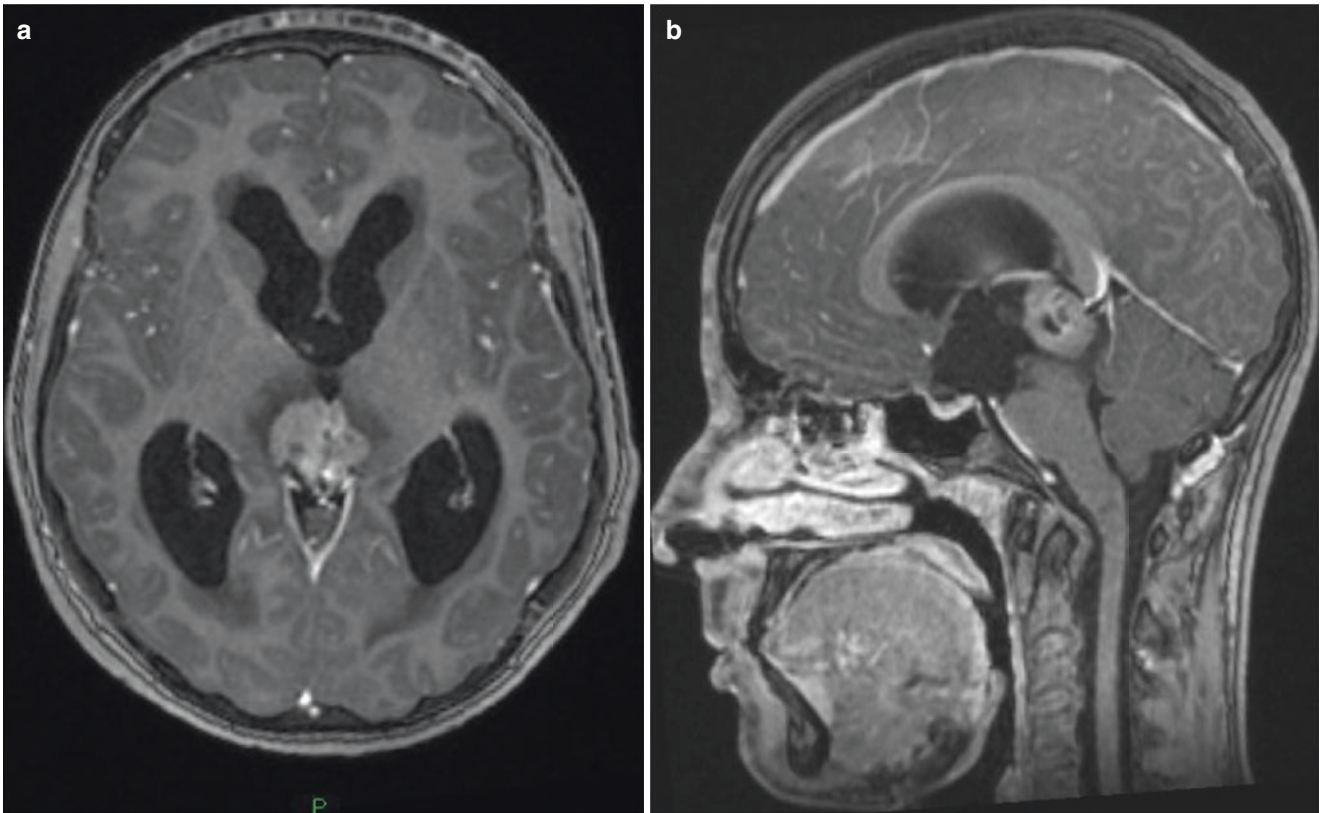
Pineal germinoma. Axial (a) and sagittal (b) post-contrast T1-weighted MR images show an enhancing pineal gland tumour, which is compressing the cerebral aqueduct, causing hydrocephalus
